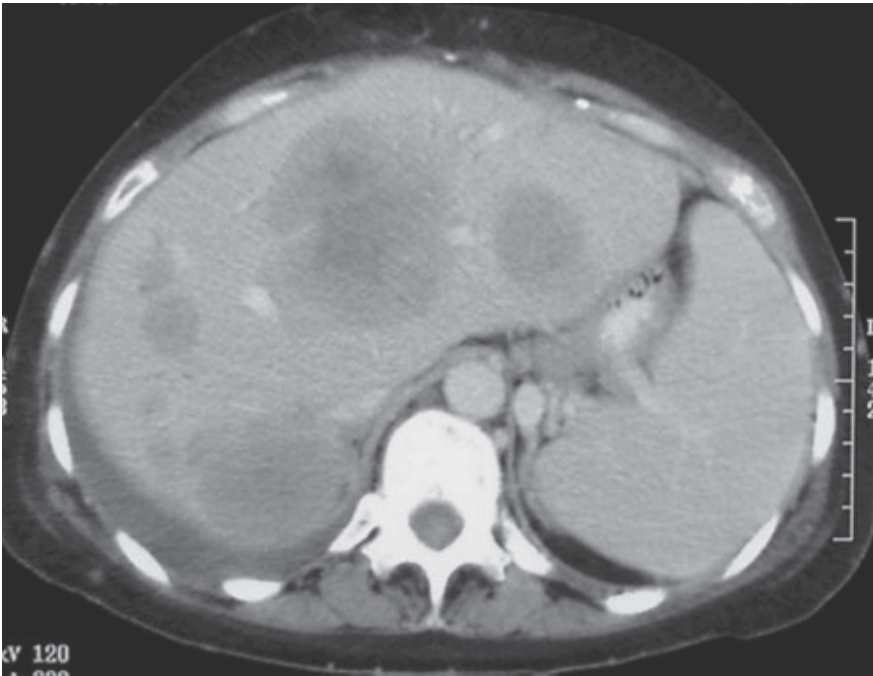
CT confirmed multiple low attenuation lesions within the liver and the presence of ascites. (Dhillon et al., 2007)
